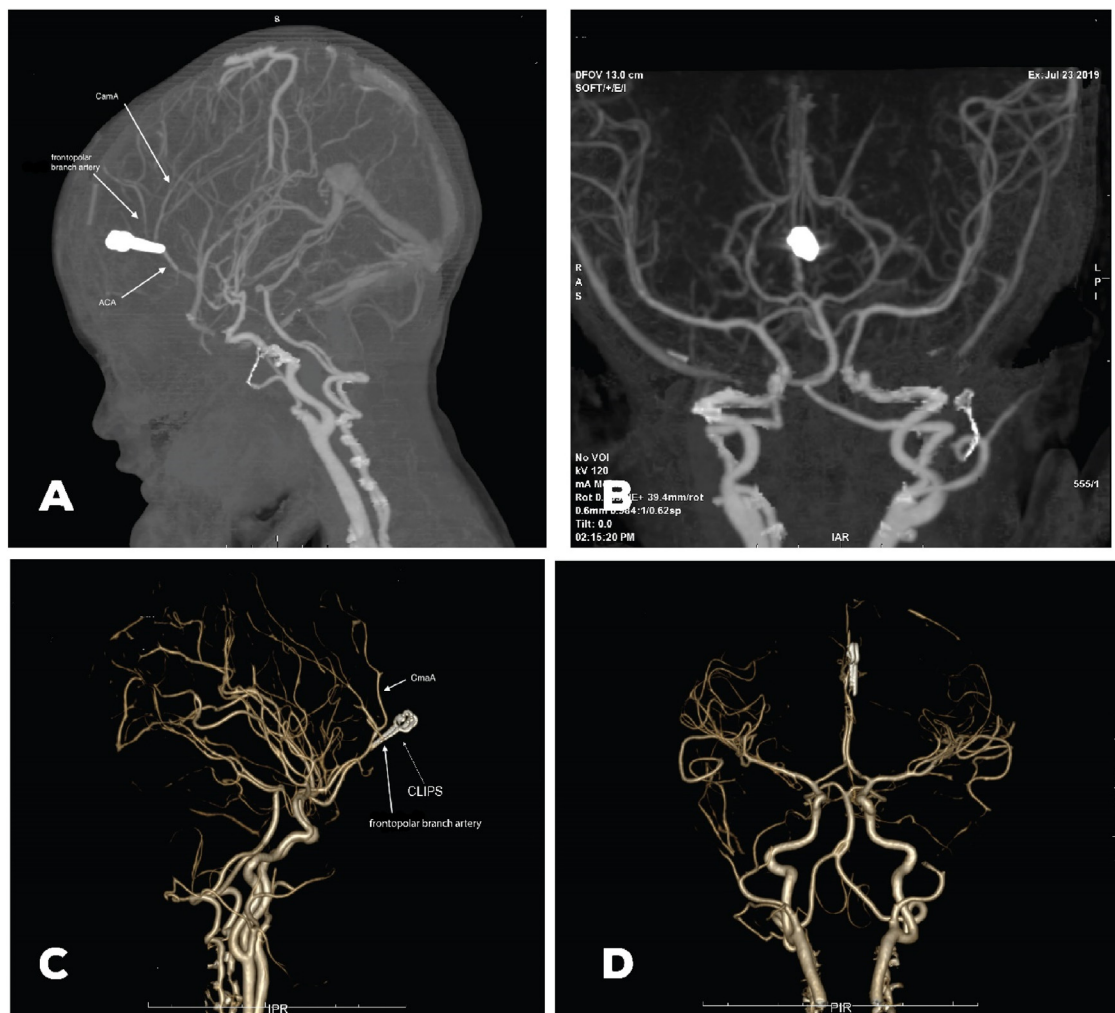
The postoperative CT angiography showed clipping of aneurysm in distal cerebral artery. CmaA: Callosalmarginal artery.
